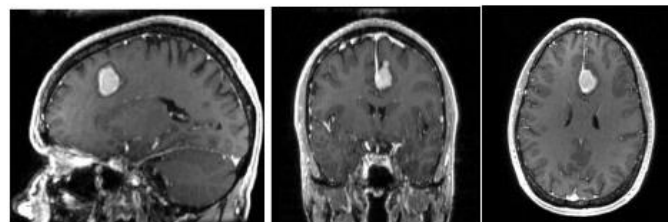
MRI Brain Tumor image Slices in different dimensions
